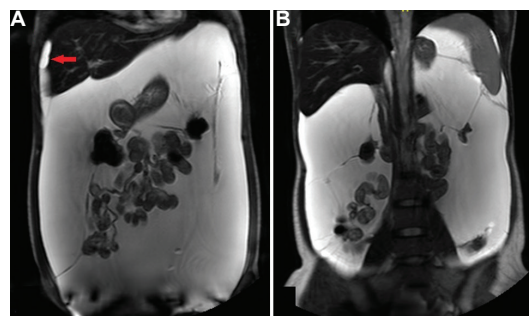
(A and B) T2-weighted coronal magnetic resonance imaging showing multi-loculated thin-walled cystic lesions filling the peritoneal cavity and scalloping the liver surface (arrow in A).
